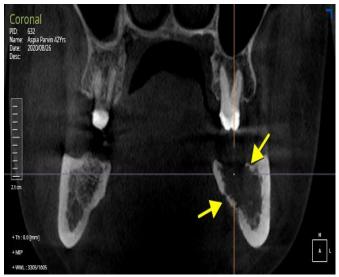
CBCT shows both buccal and lingual bone destruction
